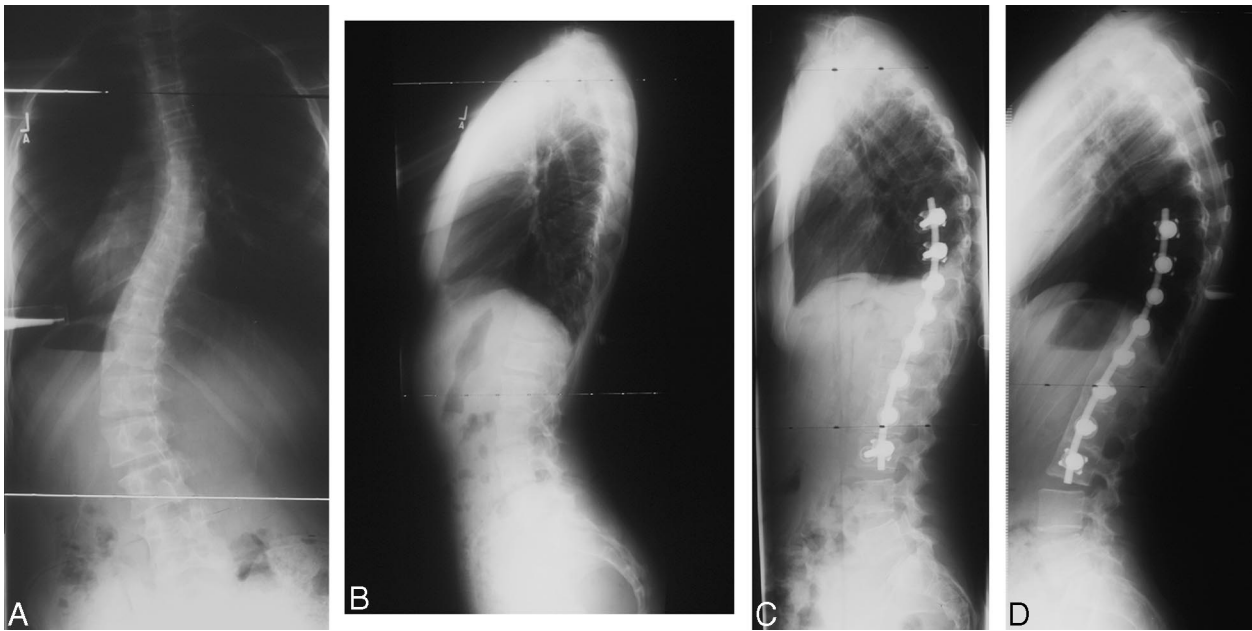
(A) Preoperative AP radiograph. Thoracolumbar primary curve with Cobb angle of 52° from T8–L3. (B) Preoperative lateral radiograph. Lordosis from T12–L3 (future LIV) is -16° , lateral plumb measures 36 mm, and lordosis below to be instrumented levels (LIV–S1) is -40° . (C) Postoperative lateral radiograph. There is a loss of lordosis from T12–LIV to -8° , the lateral plumb shifts anteriorly to 59 mm, despite increasing lordosis below the instrumentation to -51° . (D) Follow-up lateral radiograph. The lordosis from T12–LIV is -7° , the lordosis below the instrumentation increases to -61° , which shifts the lateral plumb posteriorly to 20 mm.
